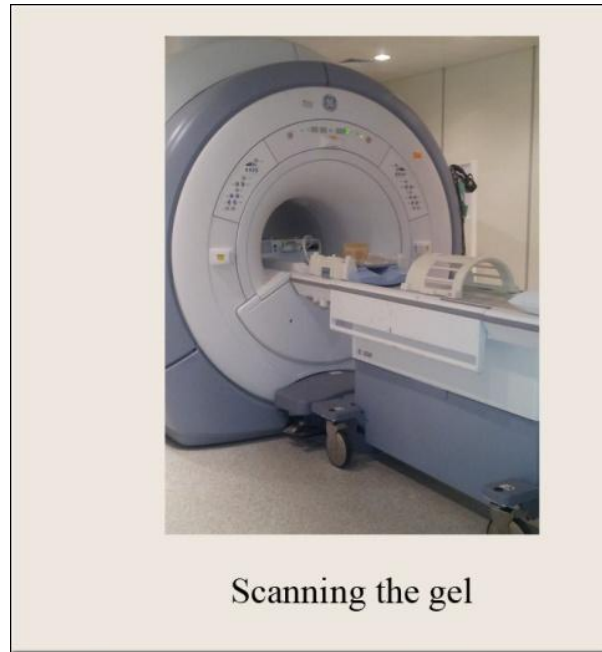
The scanning of the gel samples by 1.5T MRI
